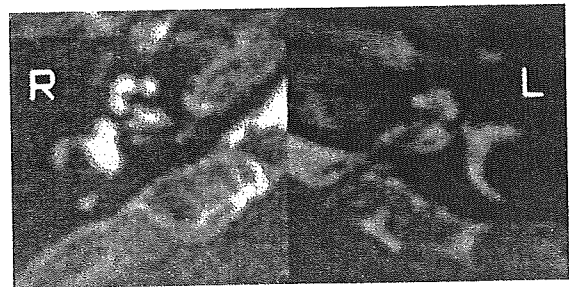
Axial three-dimensional-constructive interference on steady state (3d-CISS) MRIs. On the left side, cochlear and superior vestibular nerves are identified in the fluid (high) intensity in the IAM. However, on the right, only the superior vestibular nerve can be identified, and the narrow route to the cochlea, seen in the CT, is filled with the fluid intensity.
